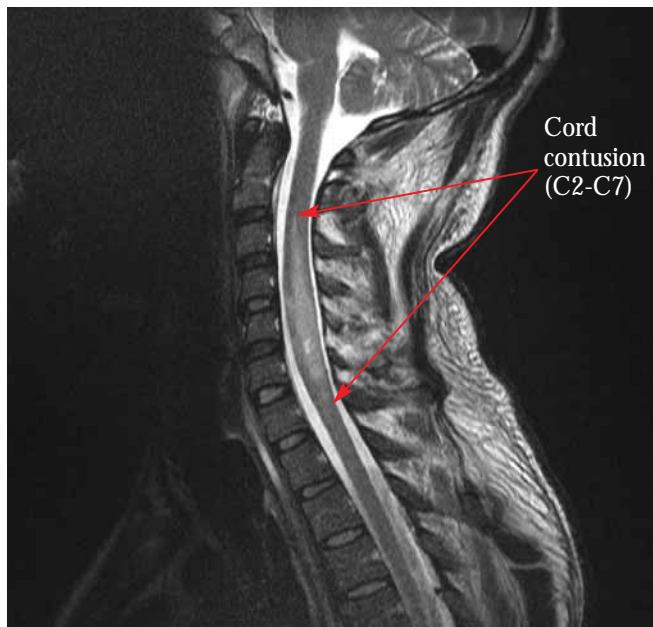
Sagittal MRI performed on return to UK demonstrating the contusion evident within the cord at 6 cervical levels.
